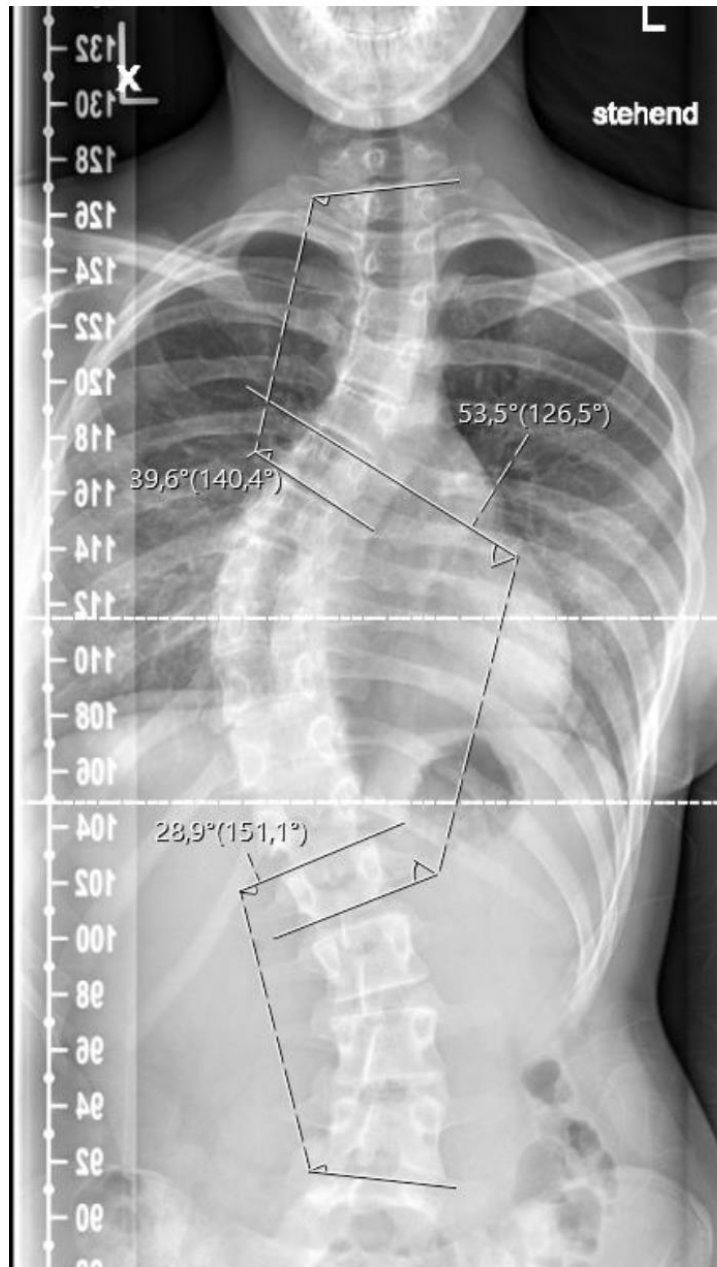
Measurement of the cobb angle from the main curve and the upper and lower minor curve in an p.a. full spine radiography.
